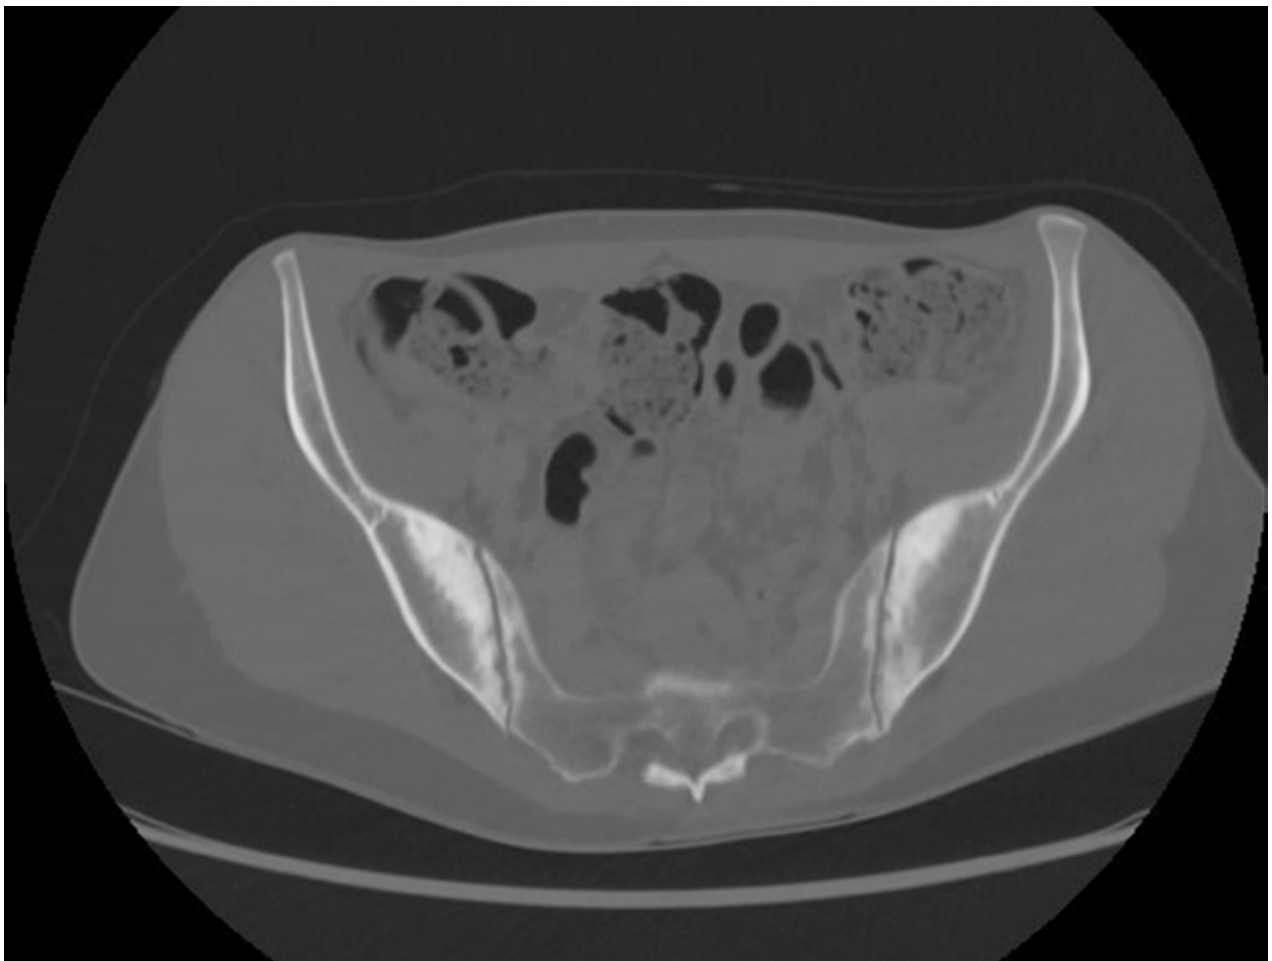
CT with bone windows confirm the triangular bone sclerosis bone of the iliac region of the sacroiliac joints bilaterally without joint space narrowing.
